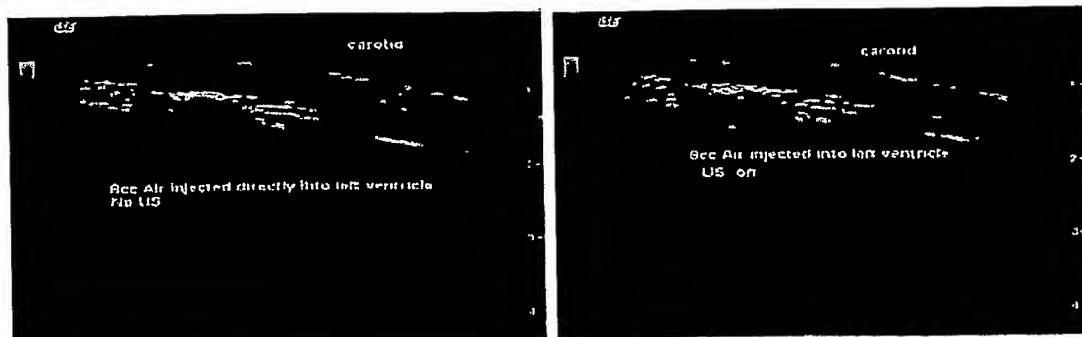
Left picture shows "shower" of air bubbles flowing through the carotid artery in the control experiment (the lumen is full of gray spots). The right picture shows the carotid artery clean of bubbles while the power ultrasound is ON (cf. the black color of the lumen)
